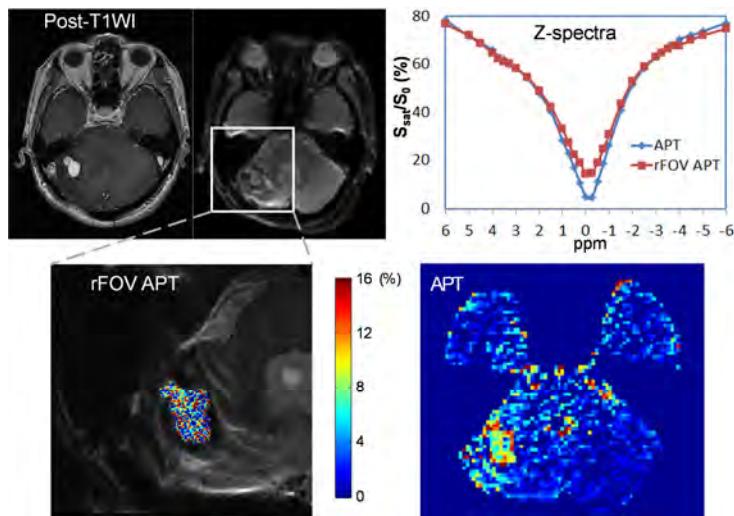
MR images for a patient with hemangioblastoma in the right cerebellum.
